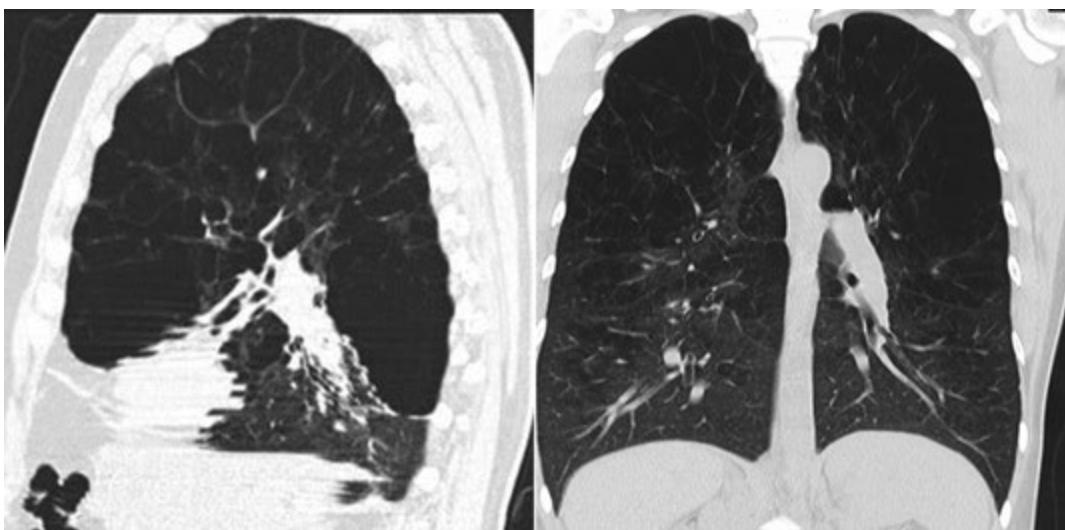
Thoracic CT image showing upper lobe predominant emphysema in a pattern suitable for lung volume reduction surgery.
